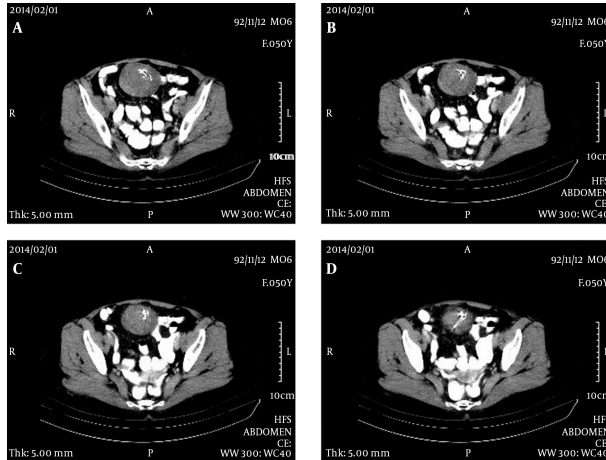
CT Scan of Abdominopelvic Region Showing an Extent of Mass (Solid Lesion With Hyper-Dense Linear Shadow Inside the Mass)
